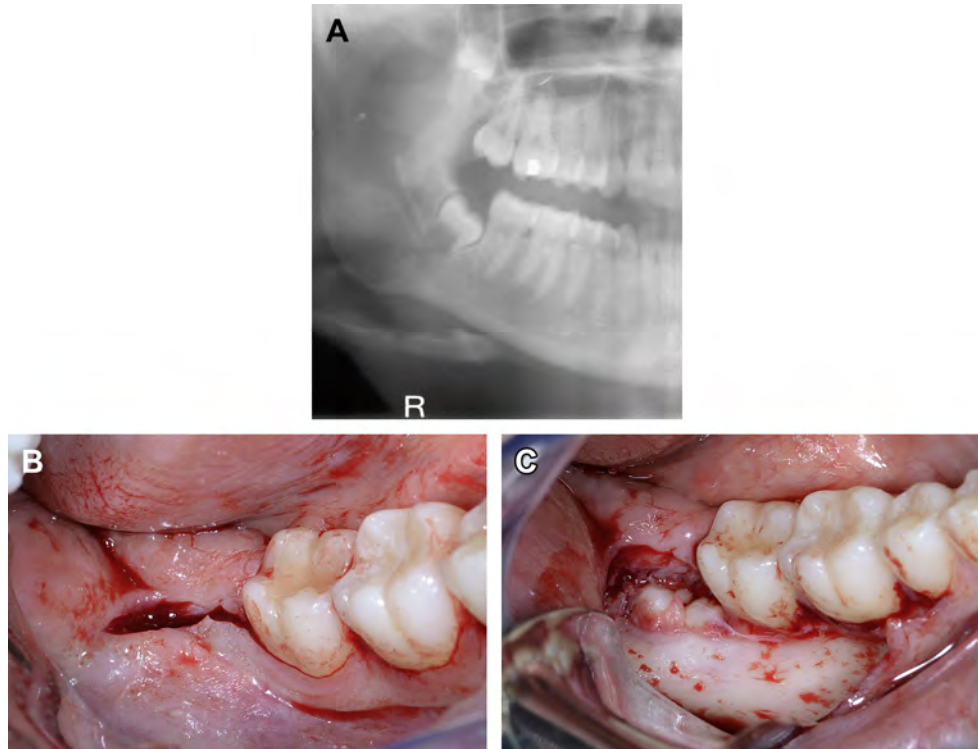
(A) Radiograph of impacted mandibular right third molar. (B) Envelope flap with posterior divergent lateral incision. (C) Envelope flap, soft tissue reflected laterally.
